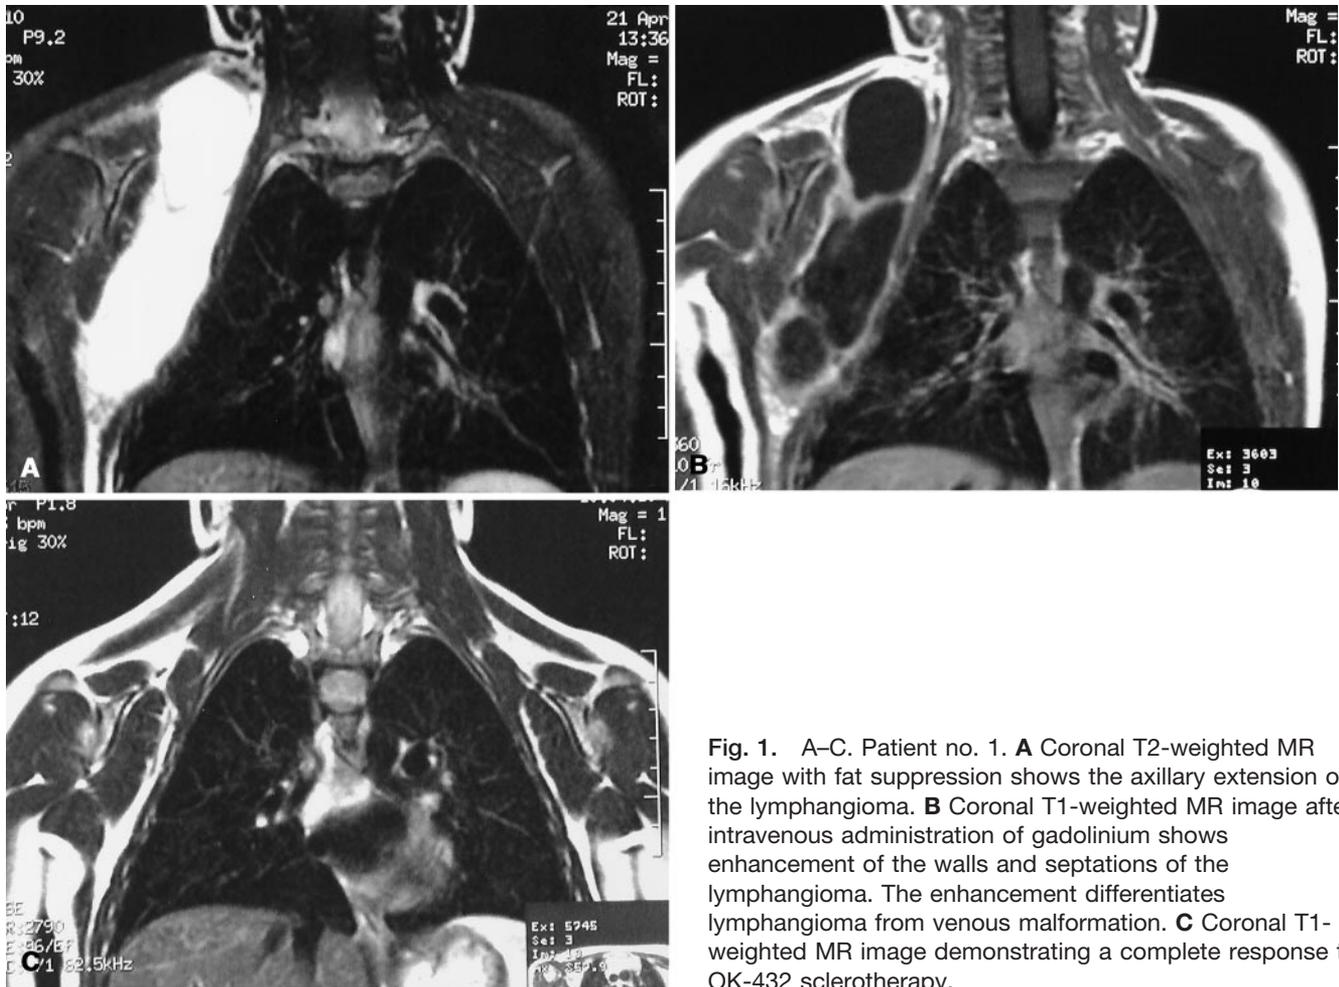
A–C. Patient no. 1. A Coronal T2-weighted MR image with fat suppression shows the axillary extension of the lymphangioma. B Coronal T1-weighted MR image after intravenous administration of gadolinium shows enhancement of the walls and septations of the lymphangioma. The enhancement differentiates lymphangioma from venous malformation. C Coronal T1-weighted MR image demonstrating a complete response to OK-432 sclerotherapy.
